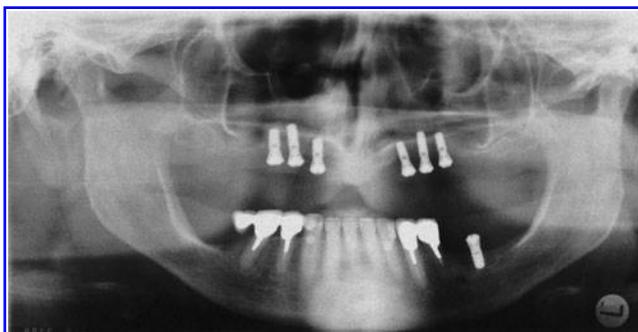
Orthopantomography control after implantation.
